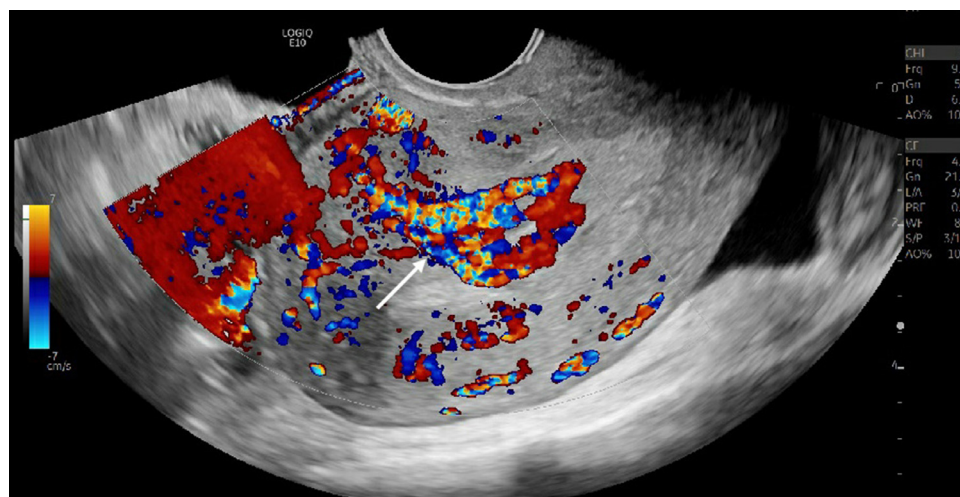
Transvaginal ultrasound images showing tortuous vessels (arrow) extending from the myometrium to the endometrium.
